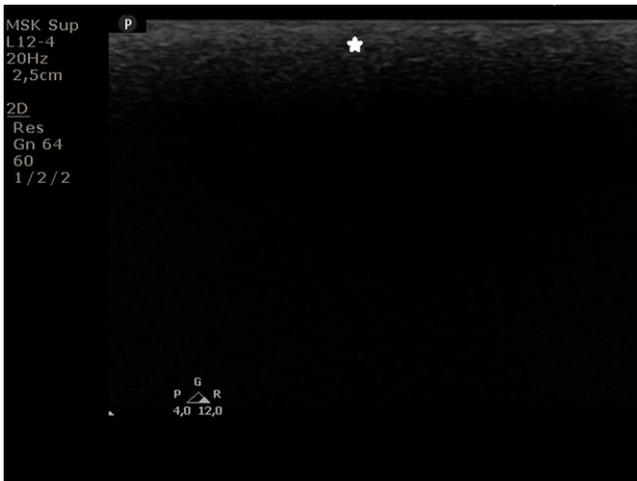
Polymethylmethacrylate visible with ultrasound
